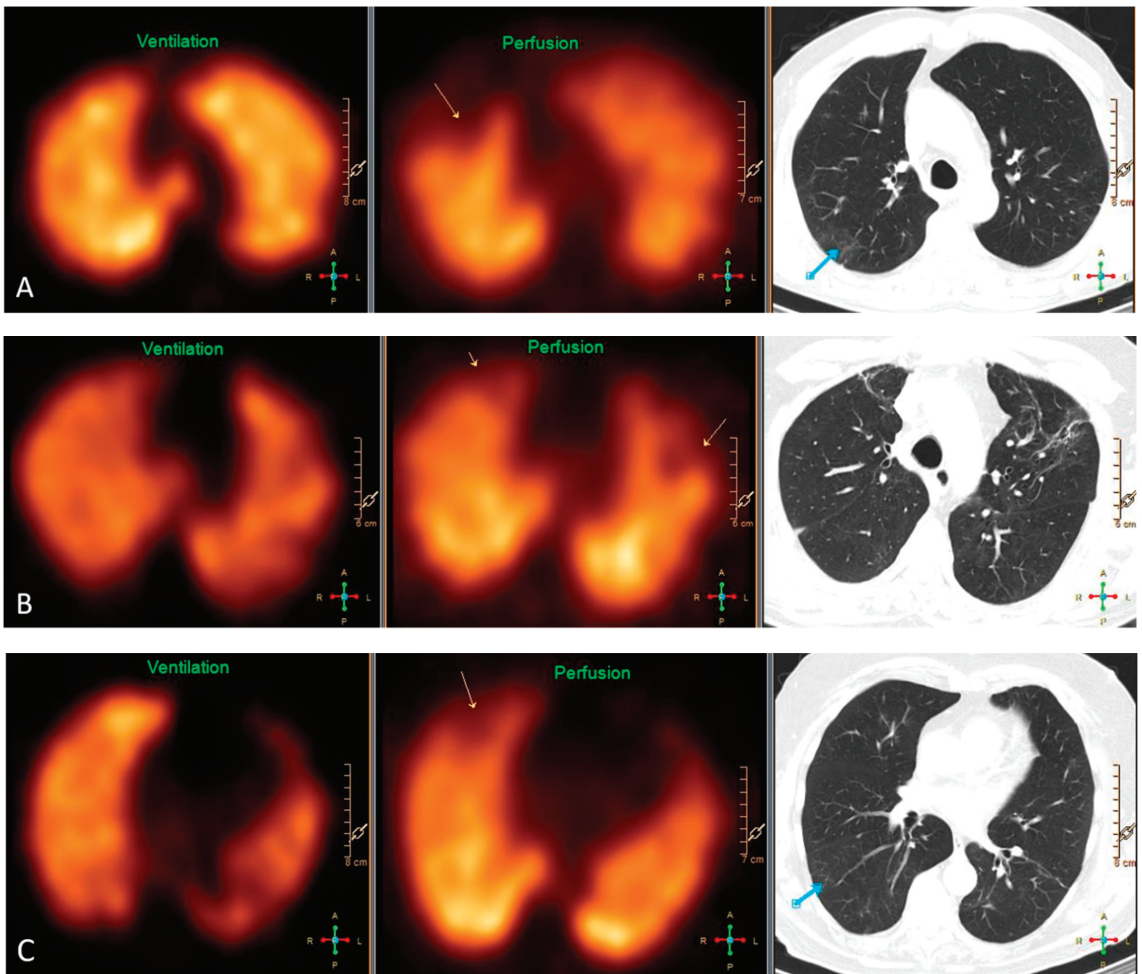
Representative findings on VQ SPECT and HRCT of three patients. (A) Pulmonary embolism in the right upper lobe causing a segmental mismatched perfusion defect on SPECT (yellow arrow) without any abnormality in the same area on HRCT. The blue arrow depicts ground-glass opacities dorsally in the right upper lobe without any defect on SPECT. (B) HRCT shows signs of fibrosis in the upper lobes causing partially mismatched subsegmental perfusion defects on SPECT (yellow arrows). (C) Pulmonary embolism in the right upper lobe causing a subsegmental mismatched perfusion defect on SPECT (yellow arrow) without any abnormality on HRCT in the same area. The blue arrow depicts discrete ground-glass opacities and signs of hypoventilation dorsally in the upper part of the right lower lobe.
